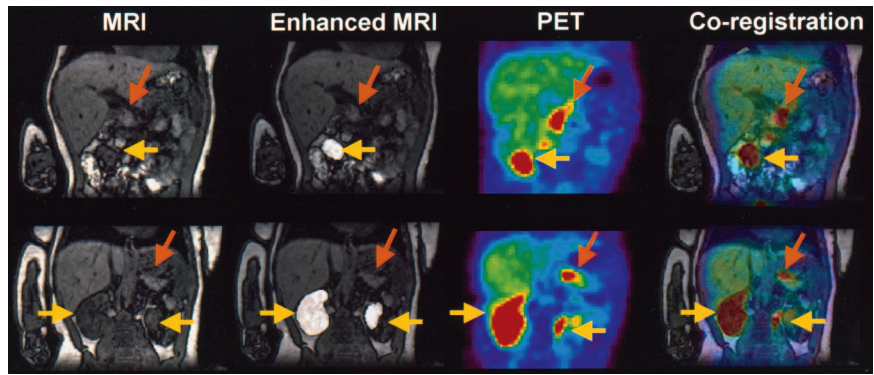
MRI, enhanced MRI, PET, and resultant coregistration images obtained from patient 8 with diffuse HI: Coregistration images confirm diffuse uptake of ^{18}F -fluoro-L-DOPA by pancreas (orange arrows = pancreas; yellow arrows = kidneys).
